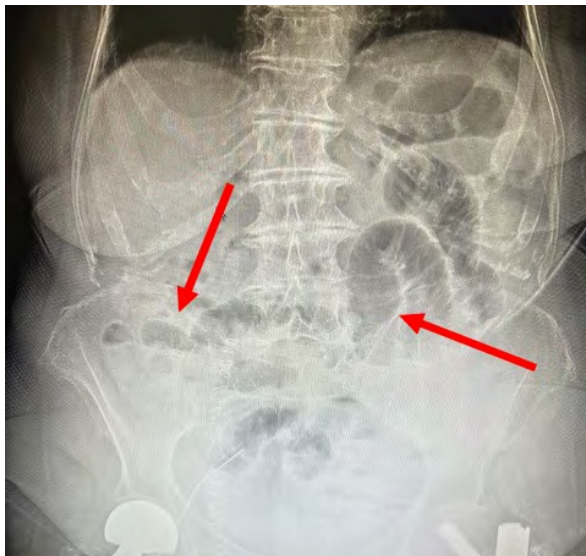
Abdominal X-ray showed short fluid levels in the mid-abdomen and distended intestinal loops. Red arrows represent described changes
